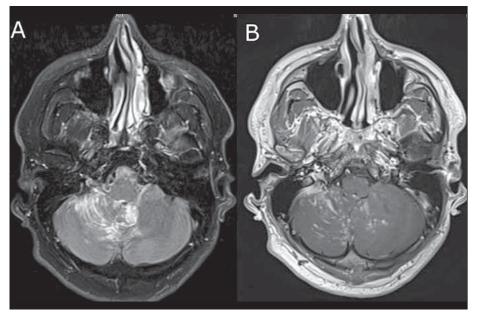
MRI with contrast medium; (A) T2 FLAIR; (B) T1 weighted image – leptomeningeal opacifying infiltrations on the base of both cerebellar hemispheres, more on the right side. FLAIR – fluid attenuated inversion recovery
